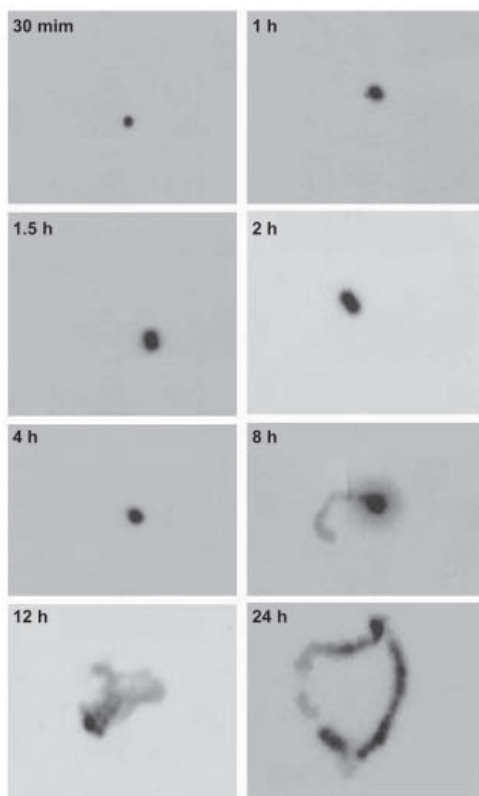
A representative gamma scintigraphs in one volunteer. Tablets remained intact in stomach after 0.5, 1, and 1.5 h; in small intestine after 2 and 4 h. Tablets partially disintegrated in colon after 8 and 12 h, and completely disintegrated and distributed as the tracer throughout the colon after 24 h.
